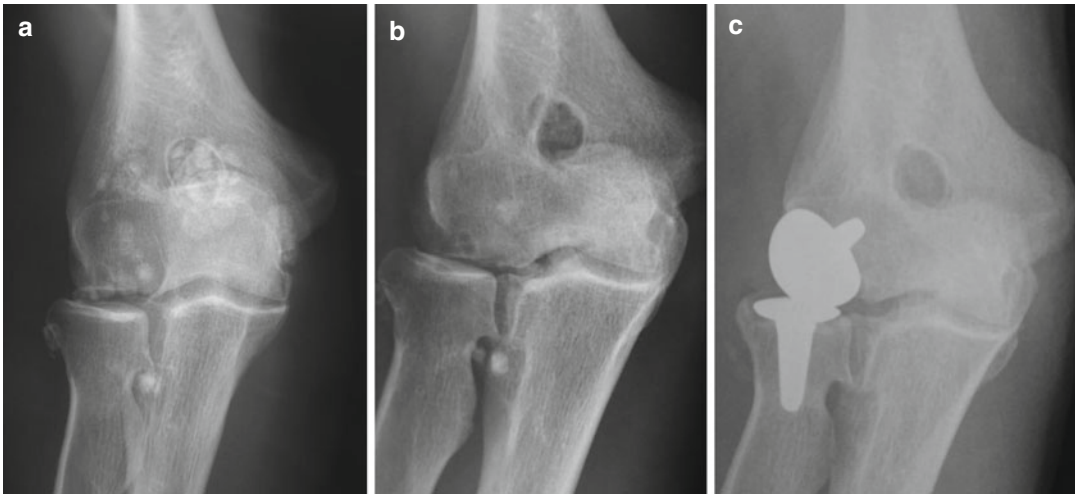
(a–c) Serial radiographs demonstrating progression of degenerative changes (osteoarthritis) in the patient with PSC whose x-ray is shown in Fig. 55.1. (a) AP radiograph prior to arthroscopic synovectomy and removal of loose bodies shown in Fig. 55.5. (b) AP radiograph 5 years later during which the patient had been free of mechanical
